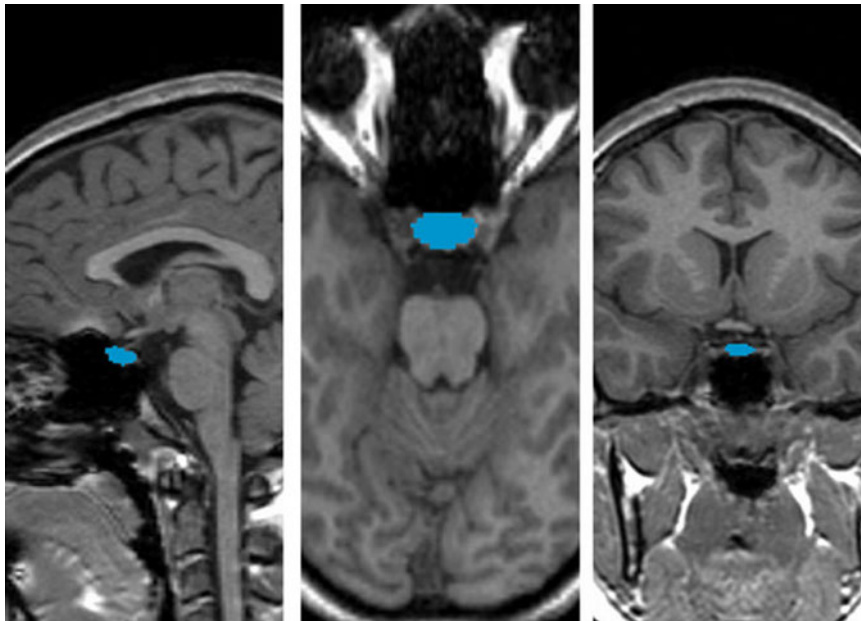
Pituitary gland in sagittal, axial and coronal magnetic resonance images. The typically distinct borders of the anterior and posterior pituitary were traced, excluding the infundibular stalk but including the posterior pituitary.
